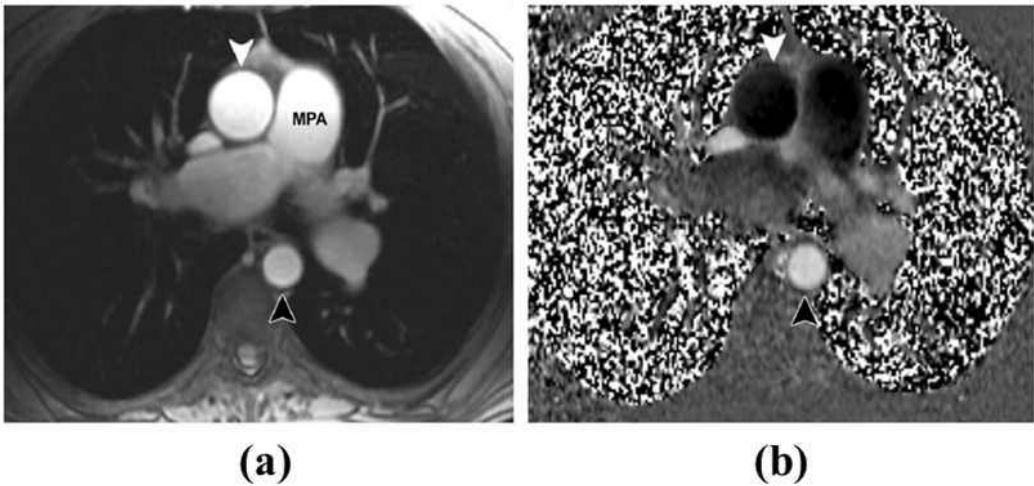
Phase-contrast imaging of the aorta. Magnitude (a) and phase (b) axial images show the ascending (image from article: MR Imaging of aortic and peripheral vascular disease, RadioGraphics, S. Tatli et al.)
